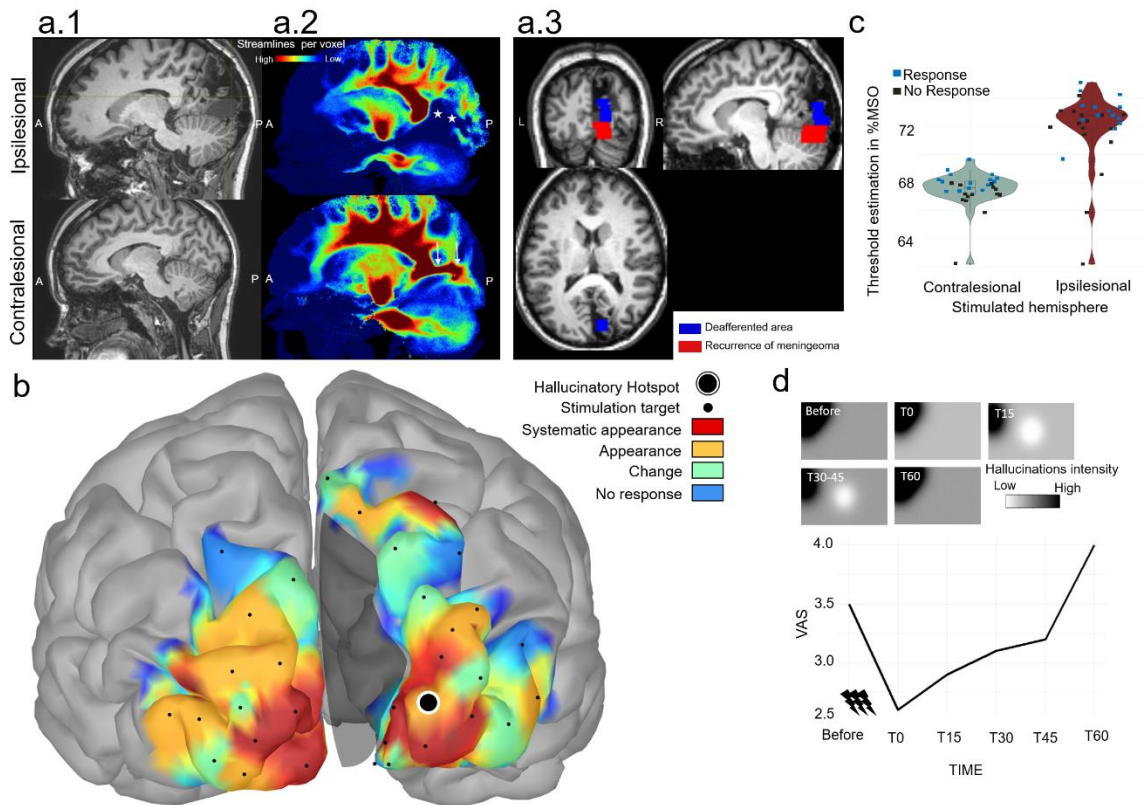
Anatomical and diffusion MRI, cortical map of TMS induced effect on hallucinations, hallucinatory thresholds and rTMS results.
